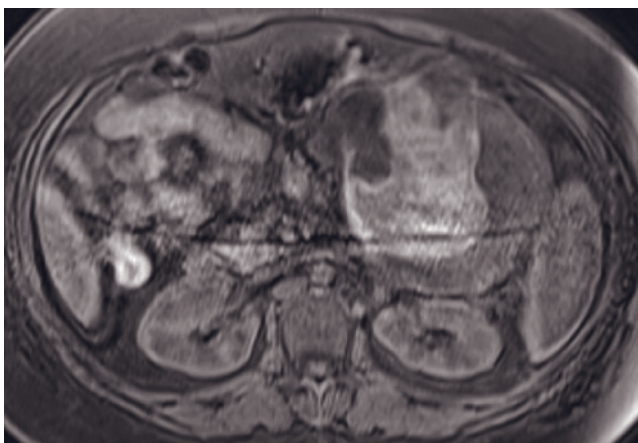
Solid and papillary epithelial neoplasm. T2-weighted fat-suppressed spin-echo (a), T1-weighted fat-suppressed SGE (b), immediate postgadolinium T1-weighted fat-suppressed SGE (c), and 90-s postgadolinium fat-suppressed SGE (d) images. A 4-cm tumor mass arises from the tail of the pancreas that is low in signal intensity on the T1-weighted image (arrow, b) and heterogeneous on the T2-weighted image (a), enhances negligibly on the immediate postgadolinium T1-weighted SGE image (c), and shows heterogeneous enhancement on the interstitial-phase image (d). This rare low-grade malignant tumor is more frequent in young females and is typically located in the tail of the pancreas. MRI may be useful in these lesions by showing cystic degeneration and hemorrhagic necrosis, which are characteristic of this entity. (Courtesy of Caroline Reinhold, MD, Dept. of Radiology, McGill University.)
